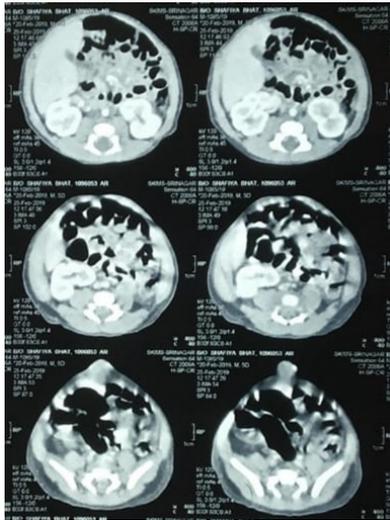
Contrast enhanced axial CT scan done on 2nd day of her birth
